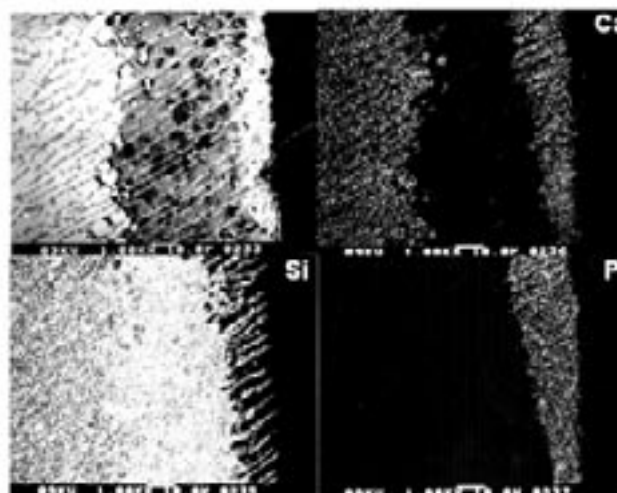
SEM image of a cross-section of pseudowollastonite after one month immersion in SBF and X-ray elemental maps of Ca, Si and P
